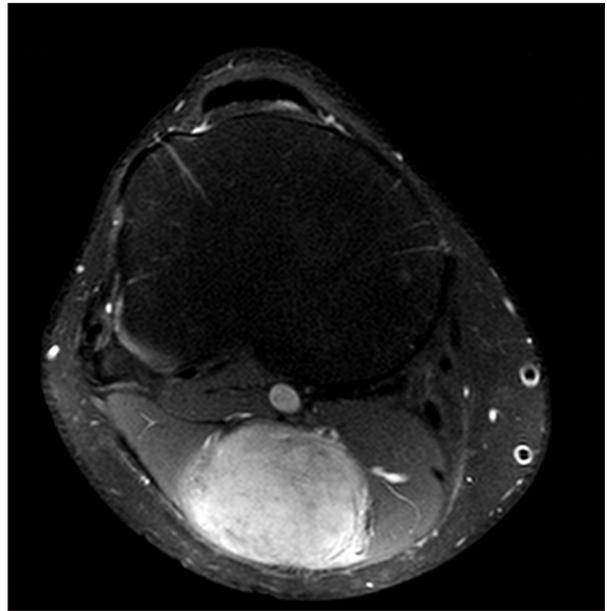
Right thigh MRI showed a 6×4×3 cm well-defined capsulated heterogeneous soft tissue mass lesion in posterior aspect of the right knee behind the popliteal vessels with extra-tumor stranding and infiltration of nearby muscle with no evidence of involvement of the popliteal fossa neurovascular bundle.
